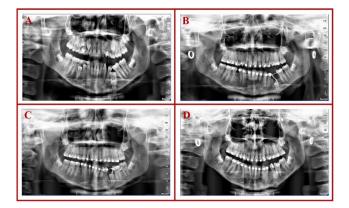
Panoramic radiograph showing orthodontic guided repositioning of impacted teeth
